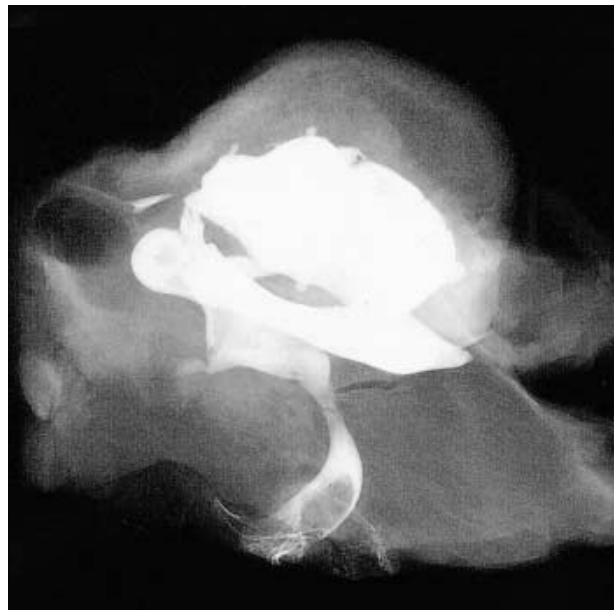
Roentgenographic findings of the cranial portion of the homunculus revealing temporal bone, zygomatic arch, and mandible.
